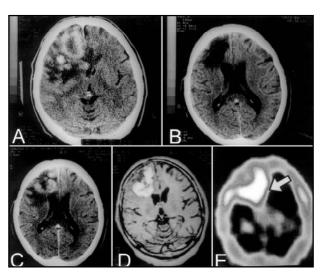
Right side frontal tumoral lesion before (A) and after (B) surgery. Reoccurrence of tumoral mass shown by CT scan (C), MRI (D), and SPECT scan (E).
